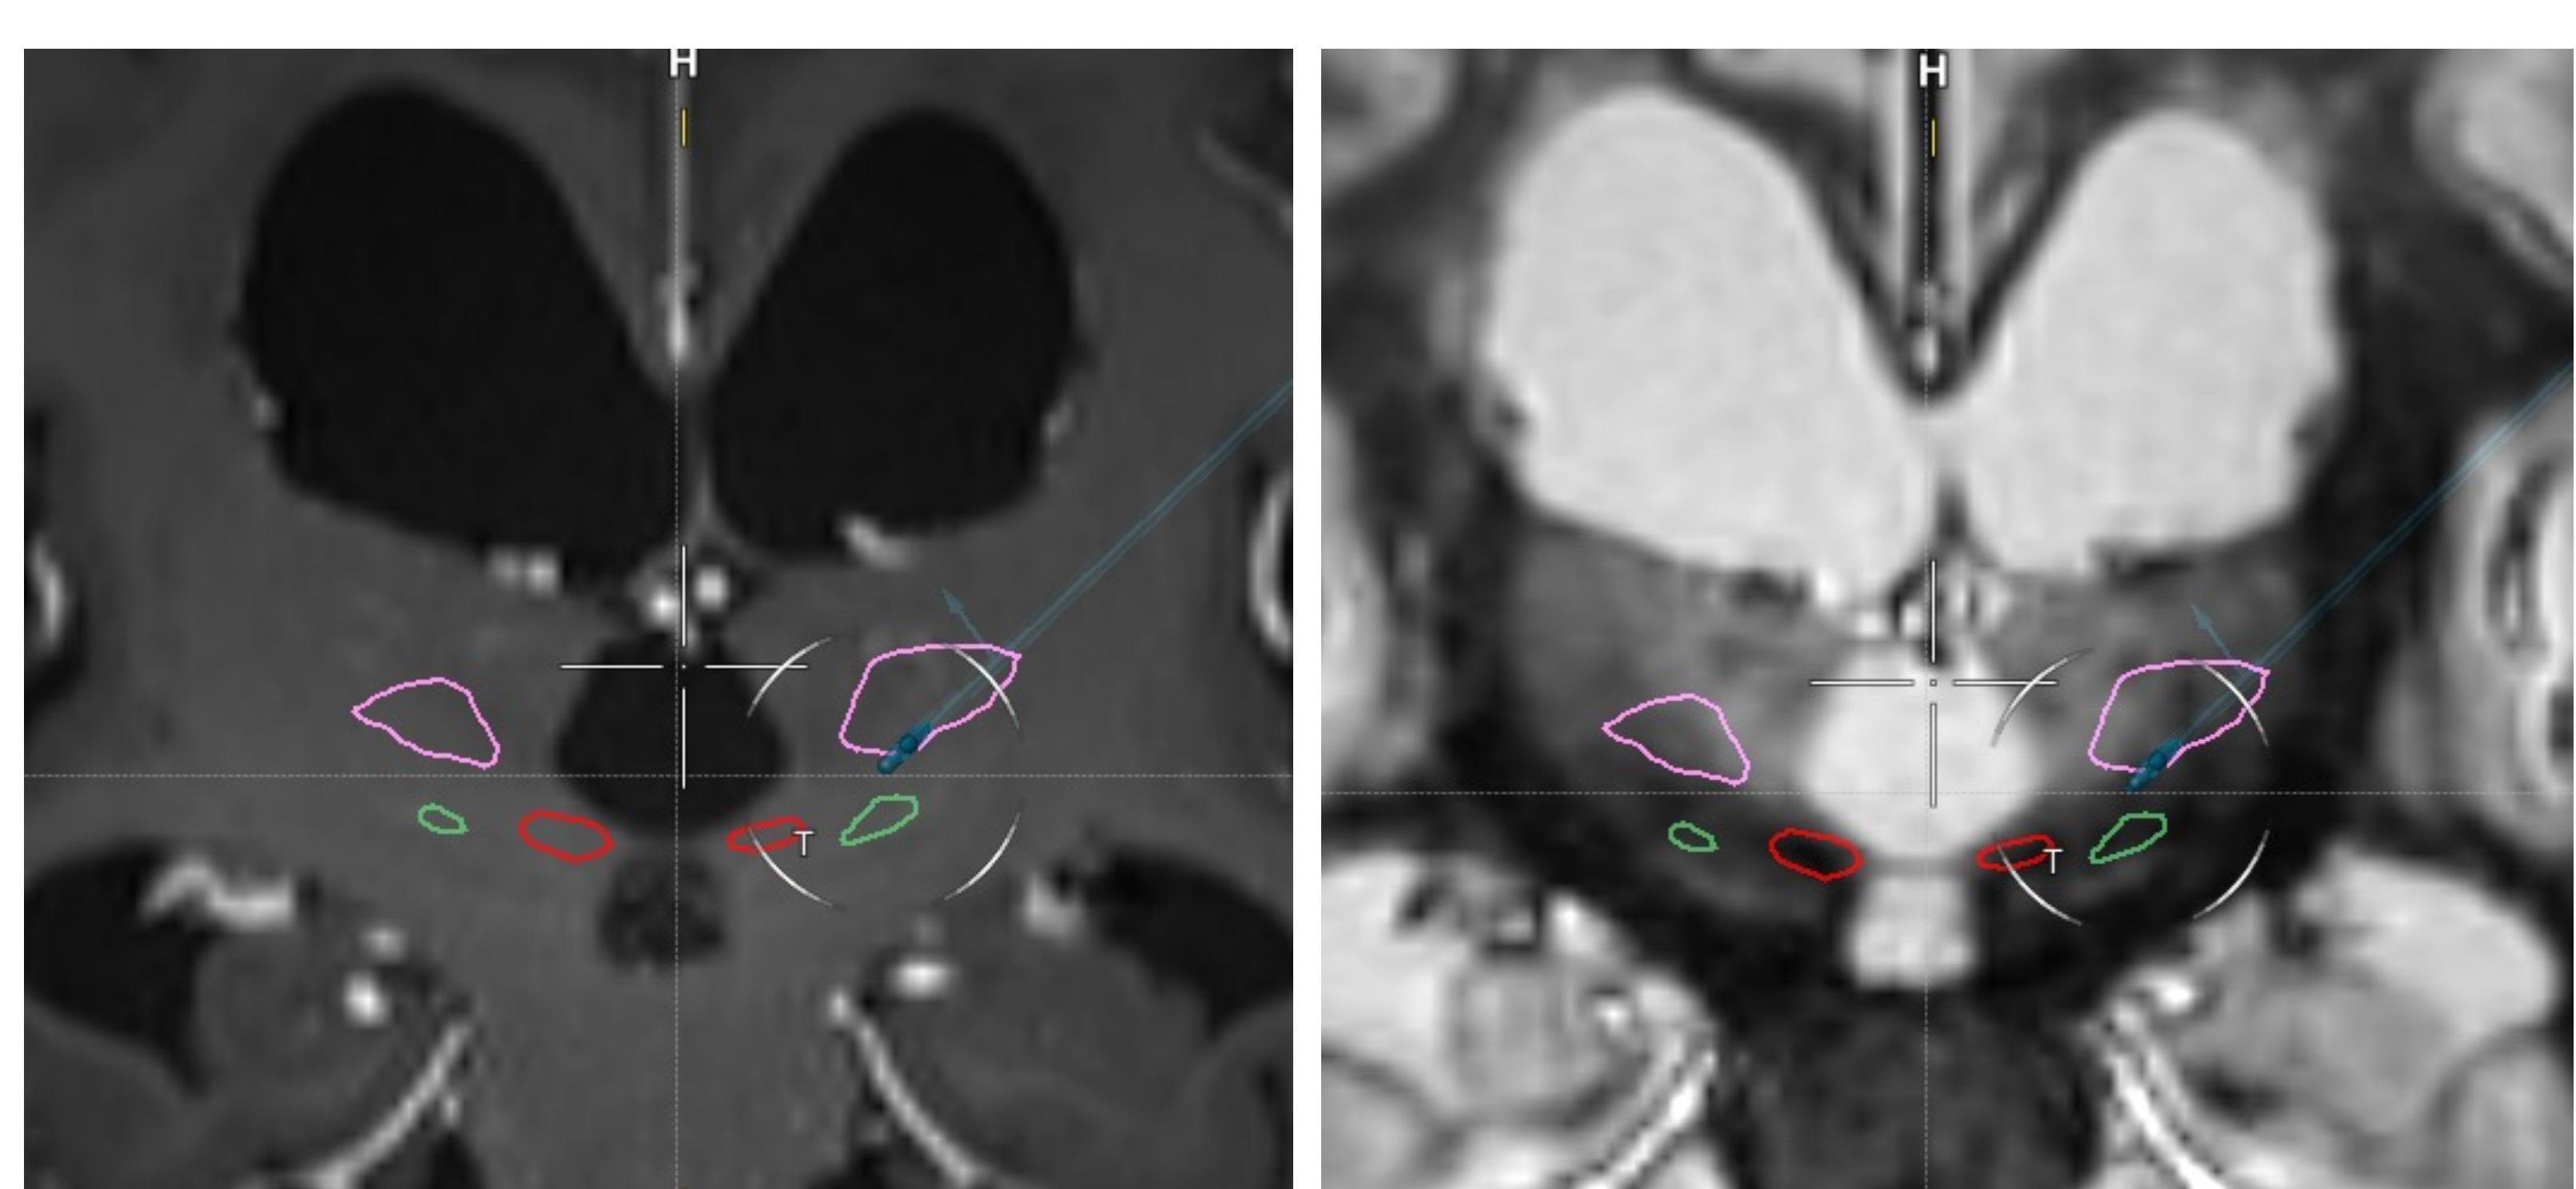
Close-up view of the VIM target in relation to the ventricles as depicted in coronal T1 and FGATIR MRI
